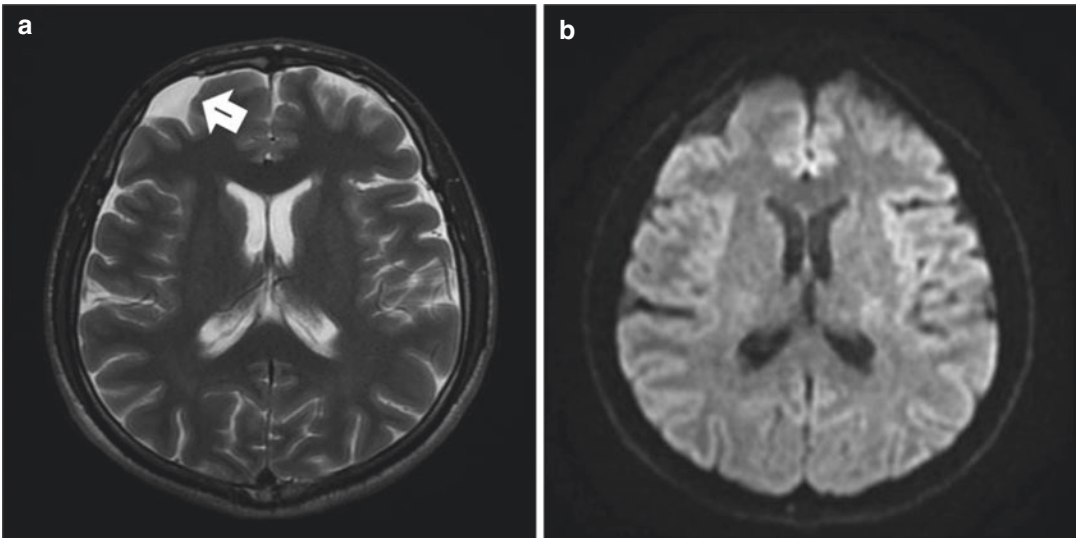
(a–c) A 32-year-old female patient with numbness in the left arm and left leg. Cystic lesion in the lateral ventricle without diffusion restriction and hyperintense on T2-weighted images. The diagnosis is AC
